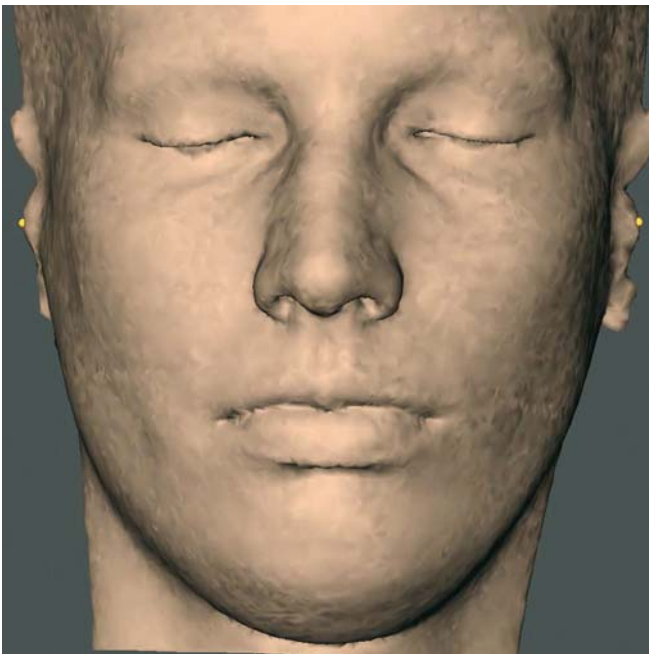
Tragion_r and tragion_l. Frontal view (3-D CT, transparent soft tissues, patient K.C.)
